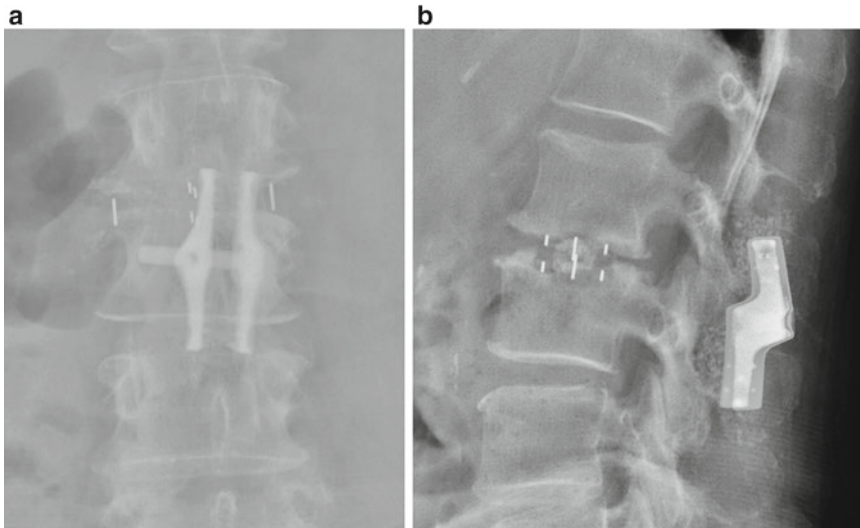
(a). Anteroposterior (AP) and (b). lateral plain radiographic images demonstrating an SPF device (Medtronic Spire Z, Memphis, TN) used to stabilize a
